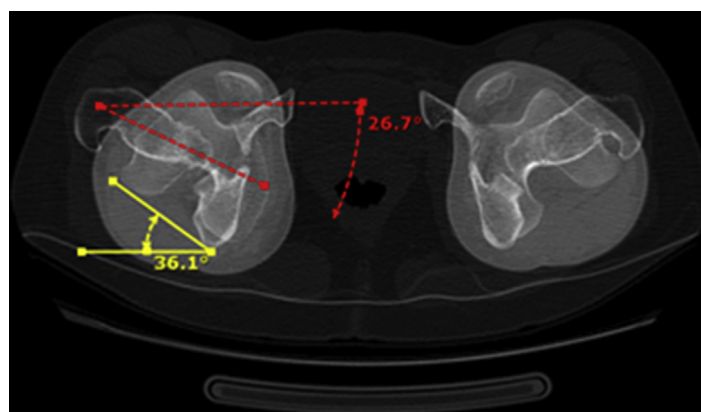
CT measurement of femoral anteversion is performed by measuring the angle formed between the long axis of the femoral neck and a line parallel to the dorsal aspect of the femoral condyles on axial CT scan.
